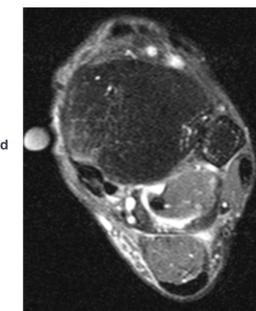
Case 2, Initial MRI: Moderately advanced tendinopathy
